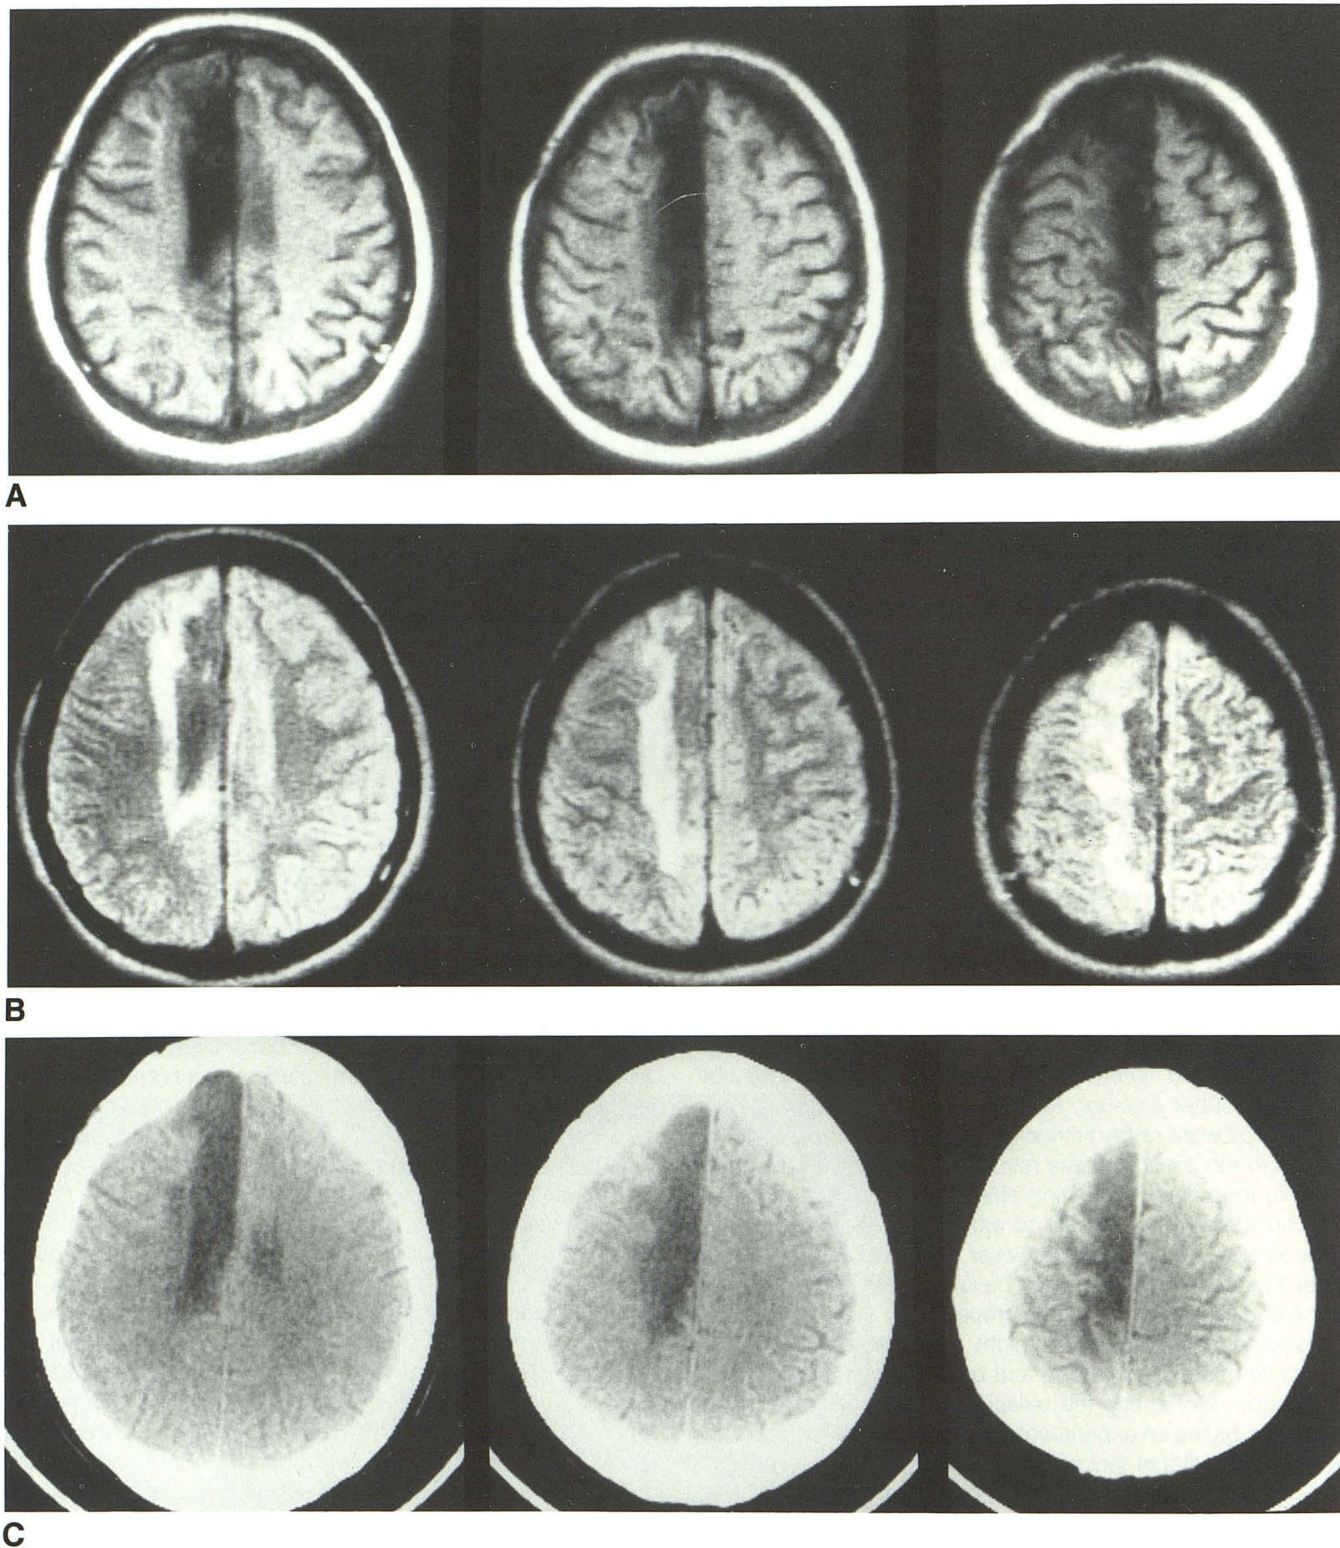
Pericallosal infarct on short TR/TE (A), long TR/TE (B), and CT (C) images.
